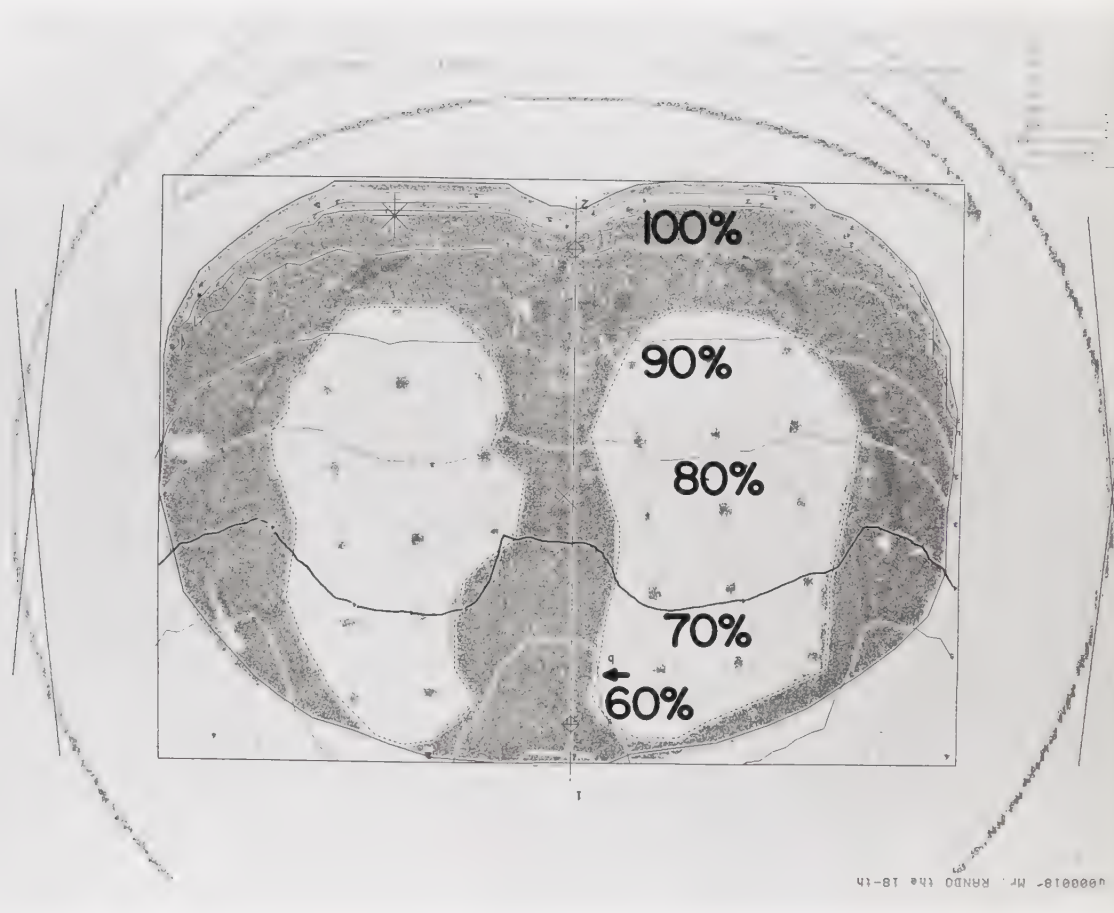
The dose distribution in a CT scan of Rando slice 18 is shown. The inhomogeneity correction was performed using the generalized Batho method (109).
